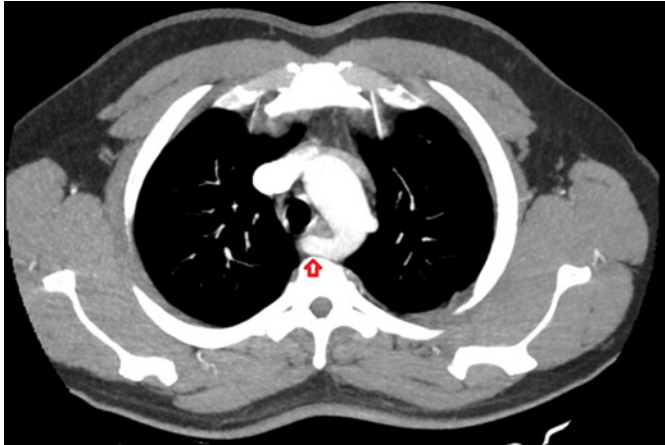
Due to suspected dysphagia *lusoria*, the patient underwent thoracic computed tomography angiography confirming an abnormal origin to the right subclavian artery (see arrow).
